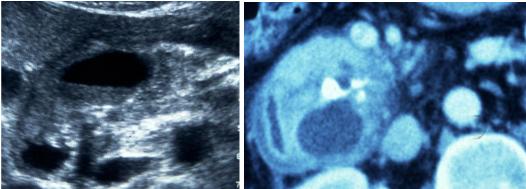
a, b Pseudocyst in chronic pancreatitis; UAS transverse (b CT image)
